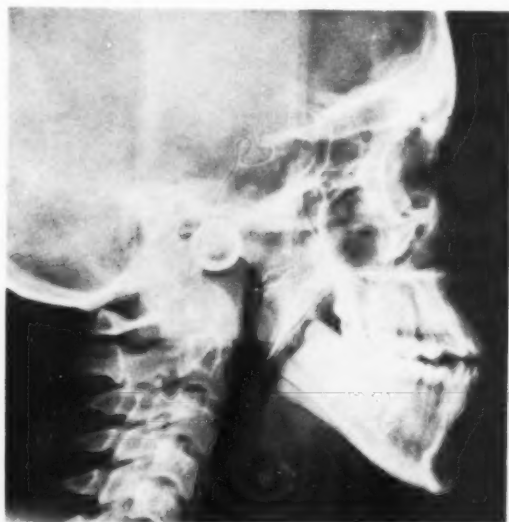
Post-operative X-ray of open ascending ramus slide.
